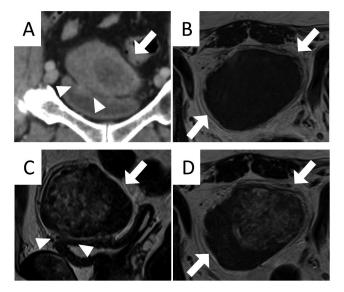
Findings of the tumor on computerized tomography (CT) and magnetic resonance imaging (MRI). White arrows indicate tumors. White arrowheads show continuity between the tumor and the bladder.
